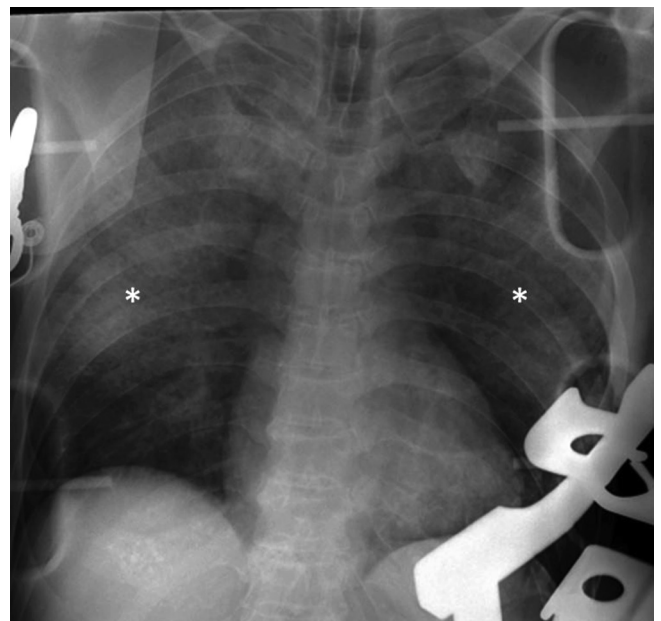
A portable chest X-ray image of the present case. Portable chest X-ray showed decreased radiolucency of both lung fields (*) without pneumothorax and successful tracheal intubation.
